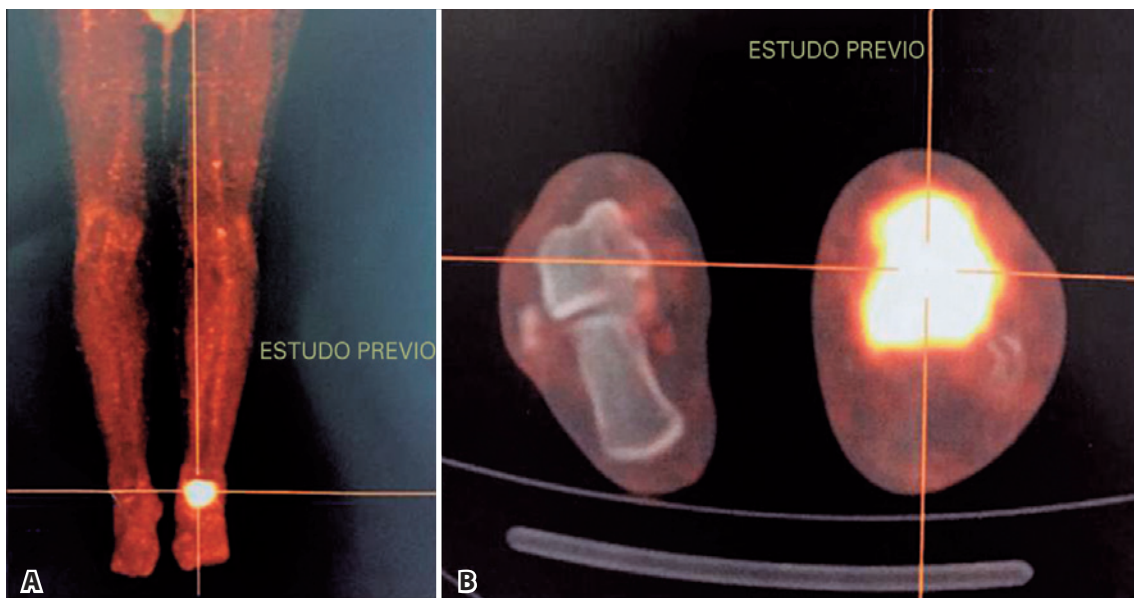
PET-CT images showing diffuse heterogeneity of the tarsal bones of the left foot with marked glycolytic activity, indicative of neoplastic processes. A) coronal image of the lower limbs. B) axial image of the tarsal bones.
